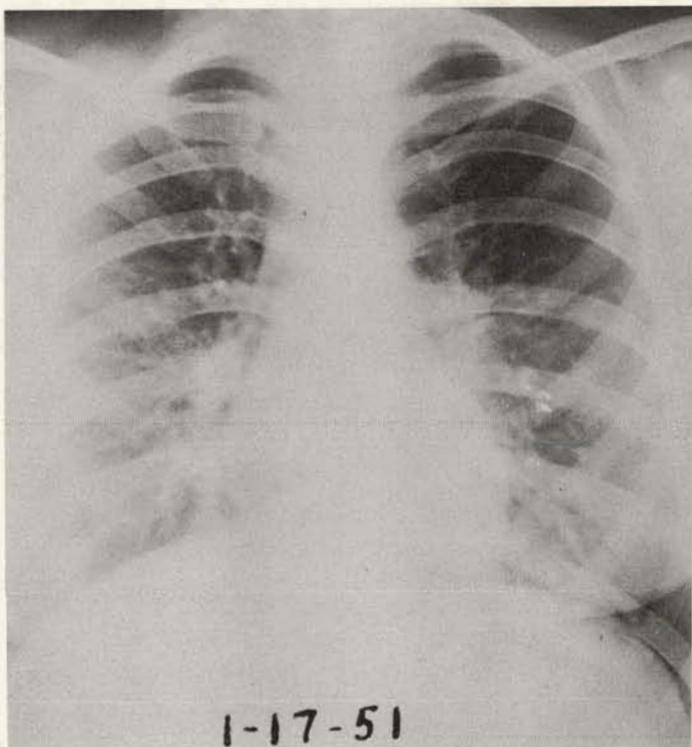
Same patient as shown in Figure 71. Roentgenograph of chest, January 17, 1951, 1 month after total thyroidectomy. I^{131} uptake was 35% in 24 hrs., chiefly in neck. I^{131} treatment, 30 mc.
